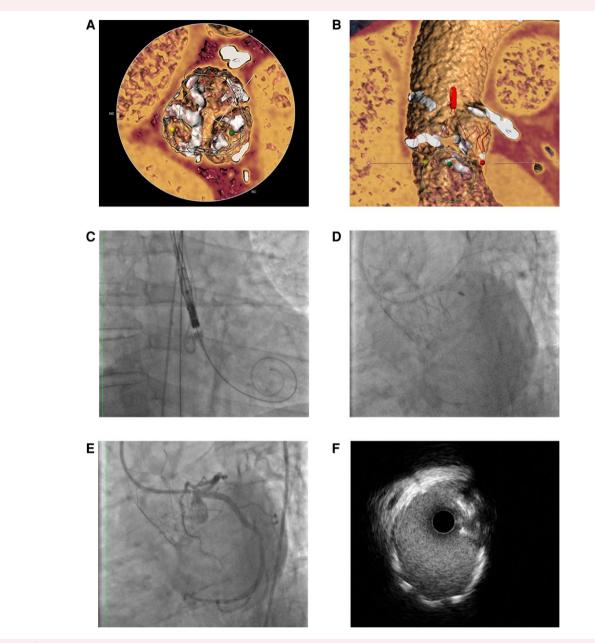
Summary of case 1. (*A* and *B*) Pre-procedural computed tomography scan showing severe aortic valve calcification involving the left main and left circumflex artery; an Acurate Neo2 M model is superimposed on the computed tomography scan suggesting that coronary take-off free from the stent frame and high likelihood of easy coronary access after transcatheter aortic valve implantation. (*C*) Cusp overlap view showing the free-stent struts for commissural alignment; (*D*) RotaPRO 1.75 burr crossing through the large stabilizing arches of the Acurate Neo2; (*E* and *F*) final angiographic and intravascular ultrasound result showing optimal stent expansion and apposition and adequate minimal stent area on the left main-left circumflex artery axis.
